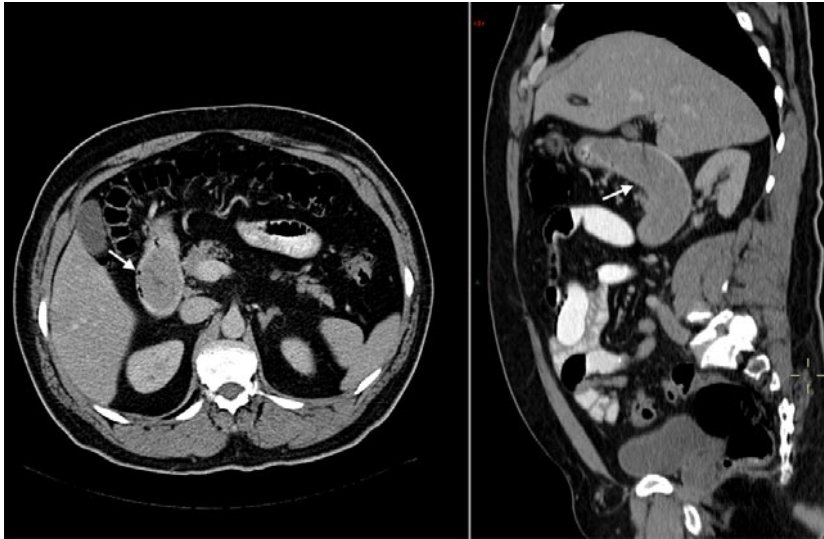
Abdominal CT scan (axial left, sagittal right) showing tumour extending from duodenal bulb to the third portion (arrow). There is no invasion of the duodenal wall or surrounding abnormal lymph nodes.
